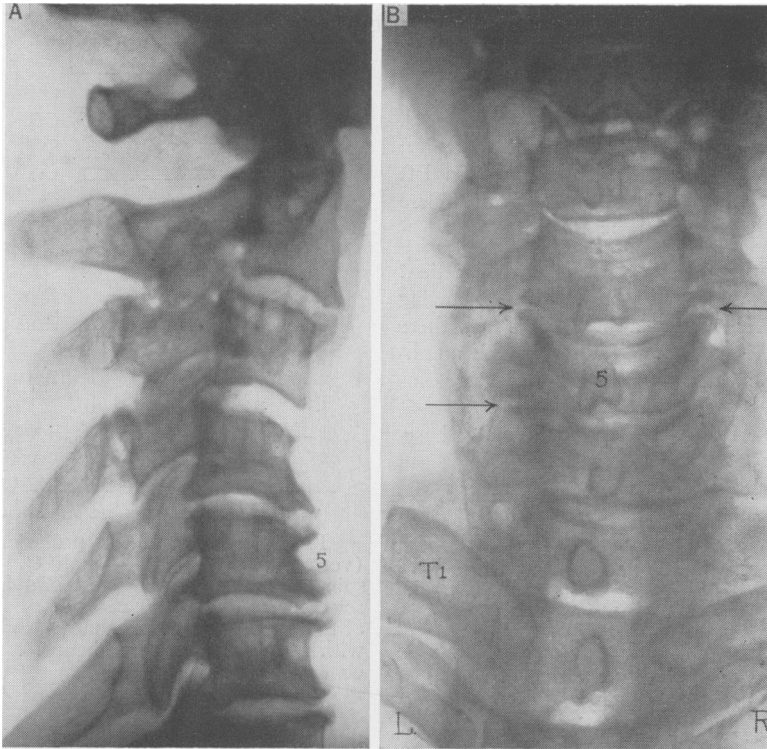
(Case 9). (A) Lateral roentgenogram showing anterior and posterior lipping with subluxation of vertebrae C₂ over C₃, C₃ over C₄. (B) AP roentgenogram showing osteophytic overgrowth of uncinates (arrows).
